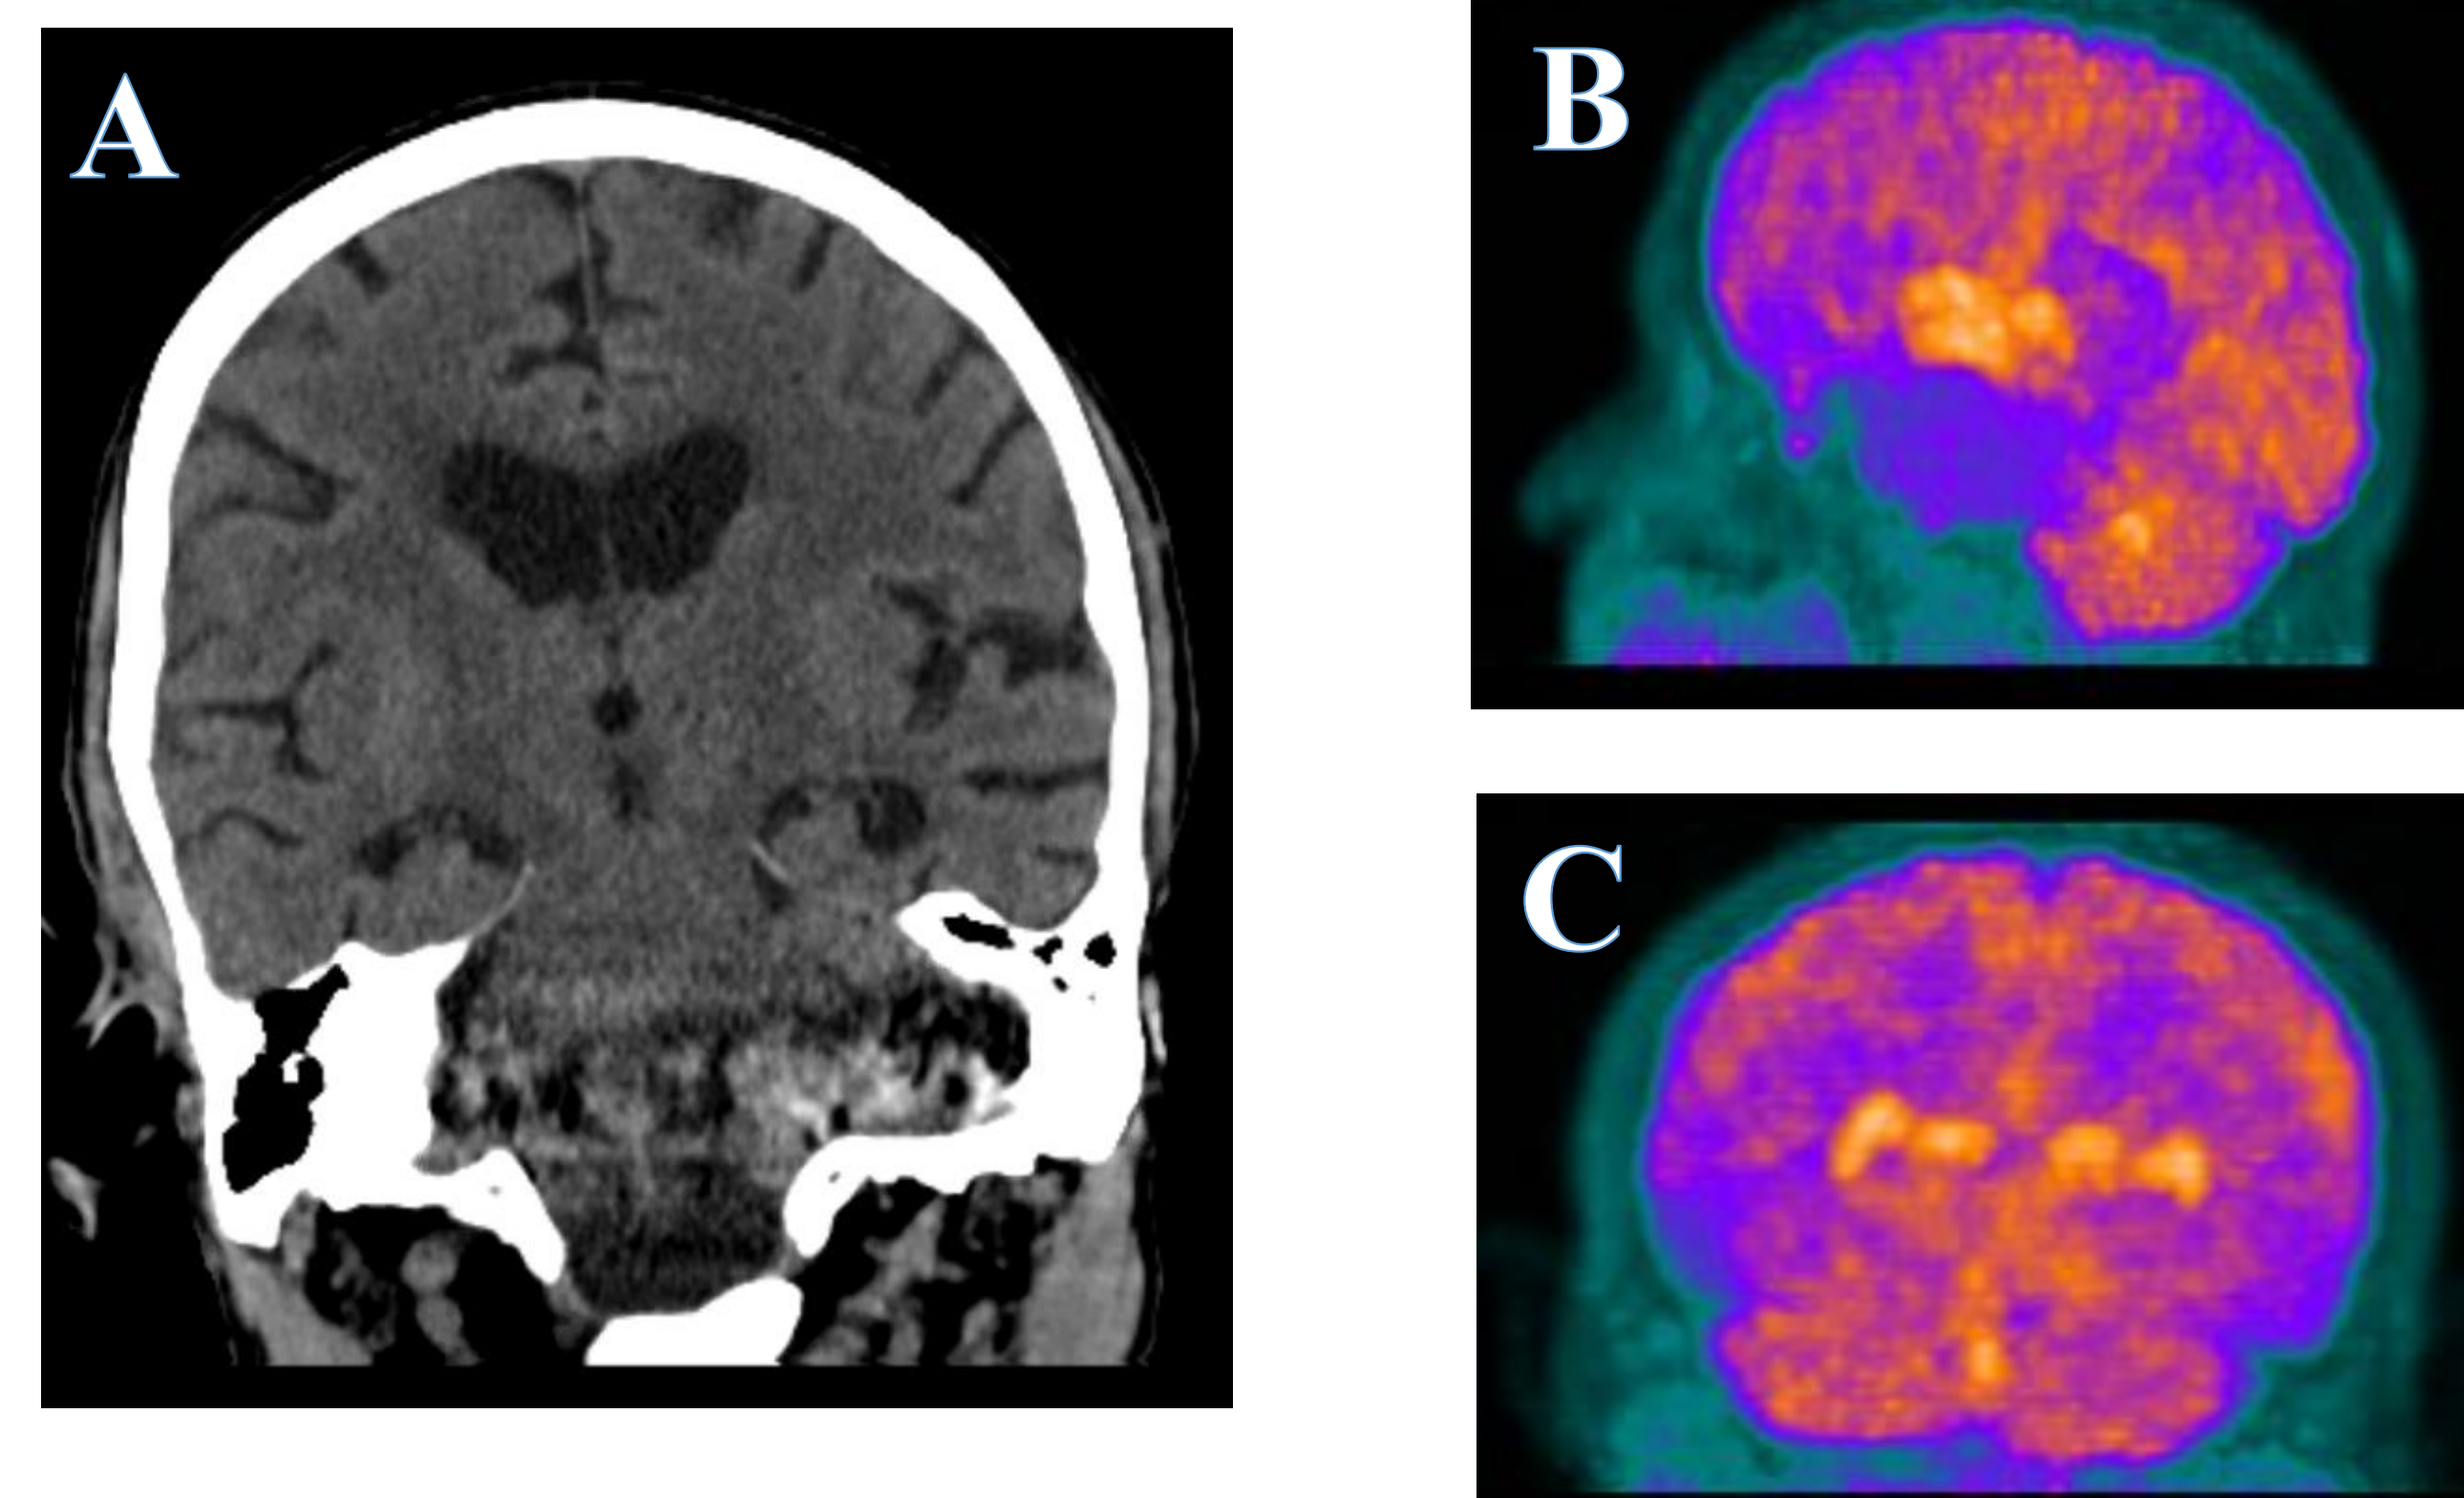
Patient Imaging (A): CT Head 2 years prior to current presentation (B)/(C): PET-CT with hypometabolism within the temporolimbic region of brain
